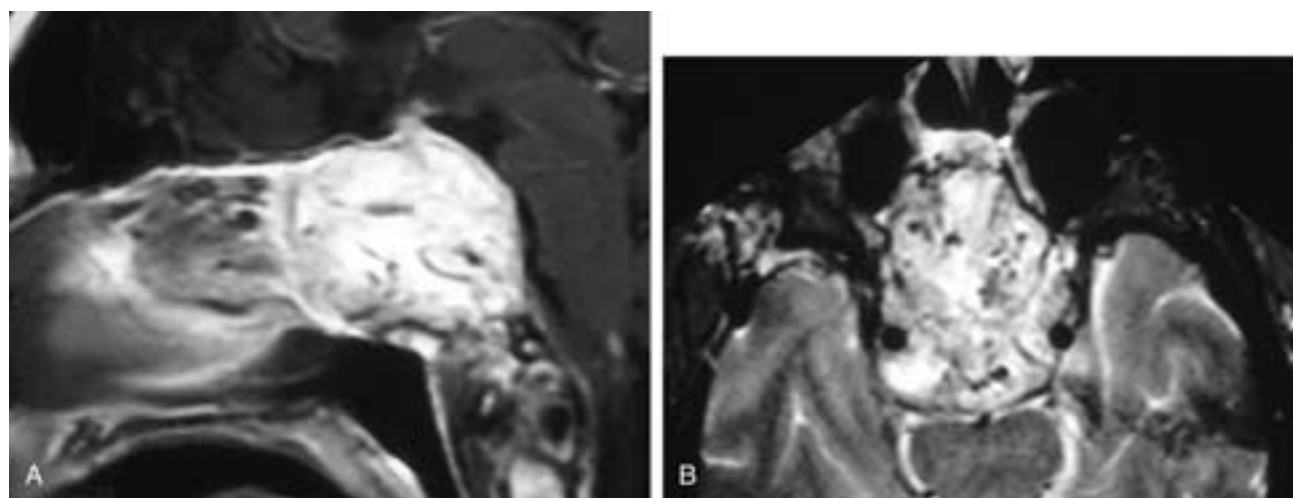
Sagittal (A) and axial (B) T1-weighted, fat-suppressed, contrast-enhanced MR images show an enhancing mass in the sphenoid sinus. There is invasion of the clivus, and there are flow voids within the tumor. This patient had a paraganglioma of the sphenoid sinus.
